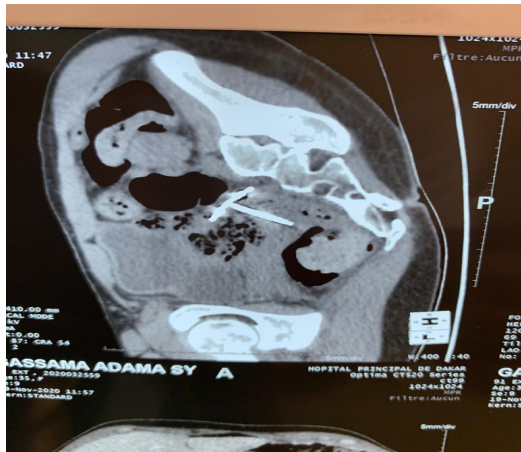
CT suspecting a recto-sigmoid localization
